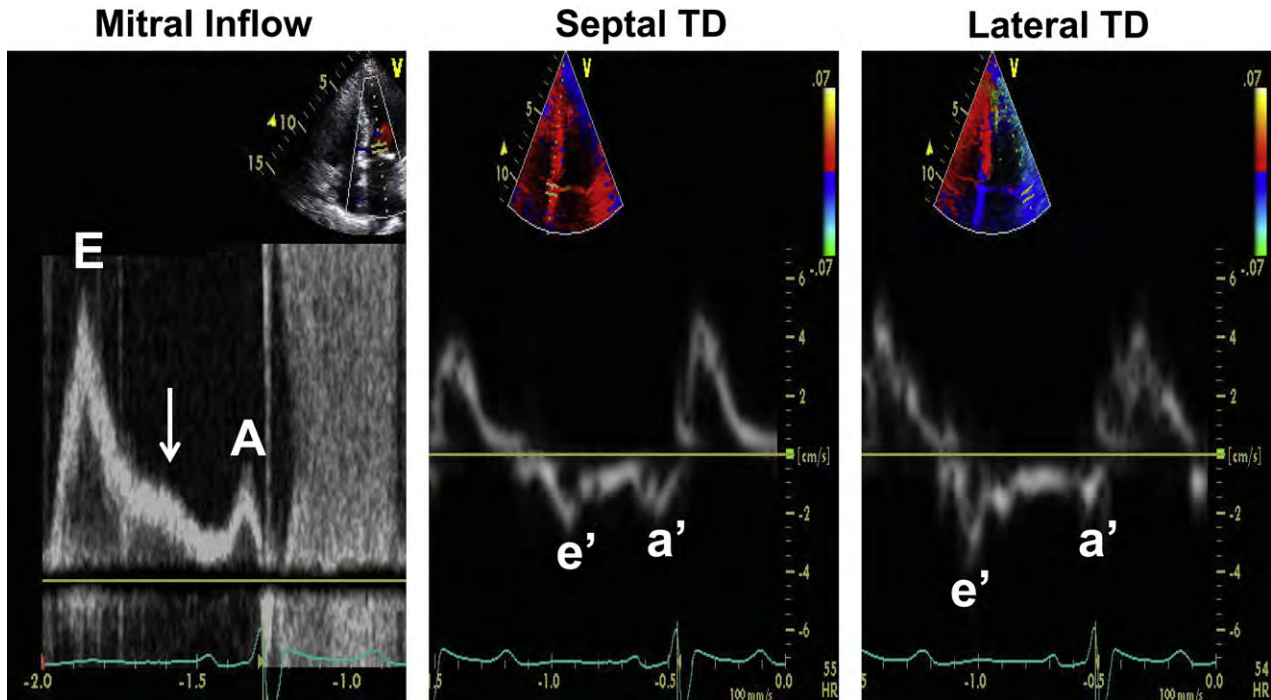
Assessment of LV diastolic function in a patient with HCM with elevated LA pressure. Mitral inflow shows a restrictive inflow pattern (E velocity, 140 cm/sec). The *arrow* points to an L velocity in mid-diastole, which is observed in the presence of impaired relaxation and increased filling pressures. Lateral annular and septal annular tissue Doppler (TD) velocities (both *e'* and *a'*) are markedly reduced consistent with severely impaired LV relaxation. The markedly increased E/*e'* ratio is consistent with increased LA pressure > 20 mm Hg. The reduced mitral A velocity with its short deceleration time and the severely reduced *a'* velocity are consistent with increased LV end-diastolic pressure. A, Peak mitral late diastolic velocity; *a'*, late diastolic TD velocity; E, peak mitral early diastolic velocity; *e'*, early diastolic TD velocity.
